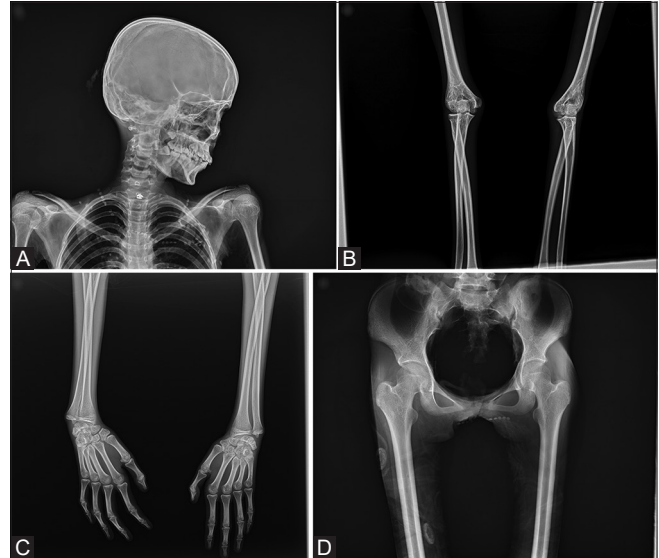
(A) X-ray lateral view of skull showing: all teeth erupted except for third molar. Crown of third molar formed to the cemento-enamel junction and pulp chamber with a trapezoidal form, Acromion process appeared and not fused. Head of humerus not fused. (B) X-ray AP view of both elbow joints showing: Medial epicondyle of humerus not fused and head of radius partially fused with shaft. (C) X-ray AP view of both hands and wrist joints showing: Head of first metacarpal fused, distal end of radius and ulna partially fused. (D) X-ray AP view of pelvis and hip joints showing: Iliac crest, ischial tuberosity appeared but not fused. Head of femur not fused.
